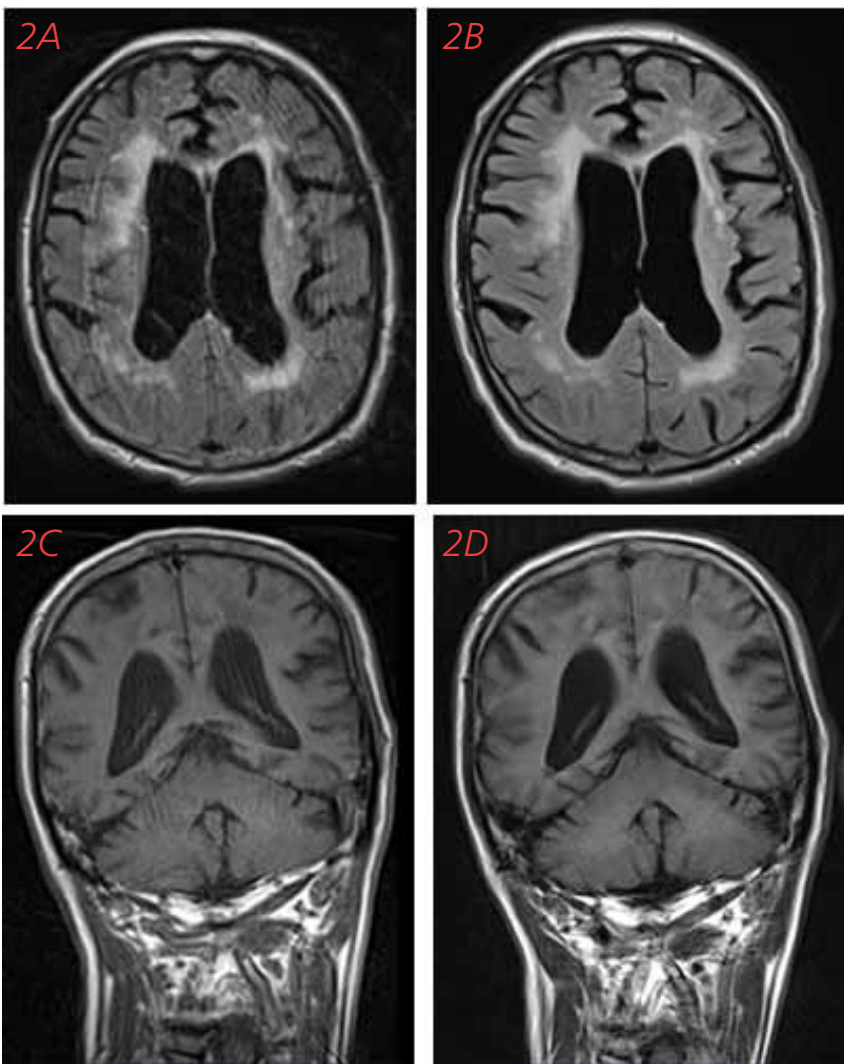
MR images of a patient who moved during imaging showing the utility of the BLADE technique for removal of the motion artifacts. Upper row: an axial FLAIR image reconstructed using the traditional technique (A) and an image reconstructed from the same data using BLADE technique (B). Lower row: a coronal T1-weighted image of the same patient reconstructed using the traditional technique (C) and an image reconstructed from the same data using the BLADE technique (D). Even this limited motion artifact seen in the traditional images can hinder the structural analysis of the brain while removal of the artifacts enables visualization of the anatomy and pathologies.
